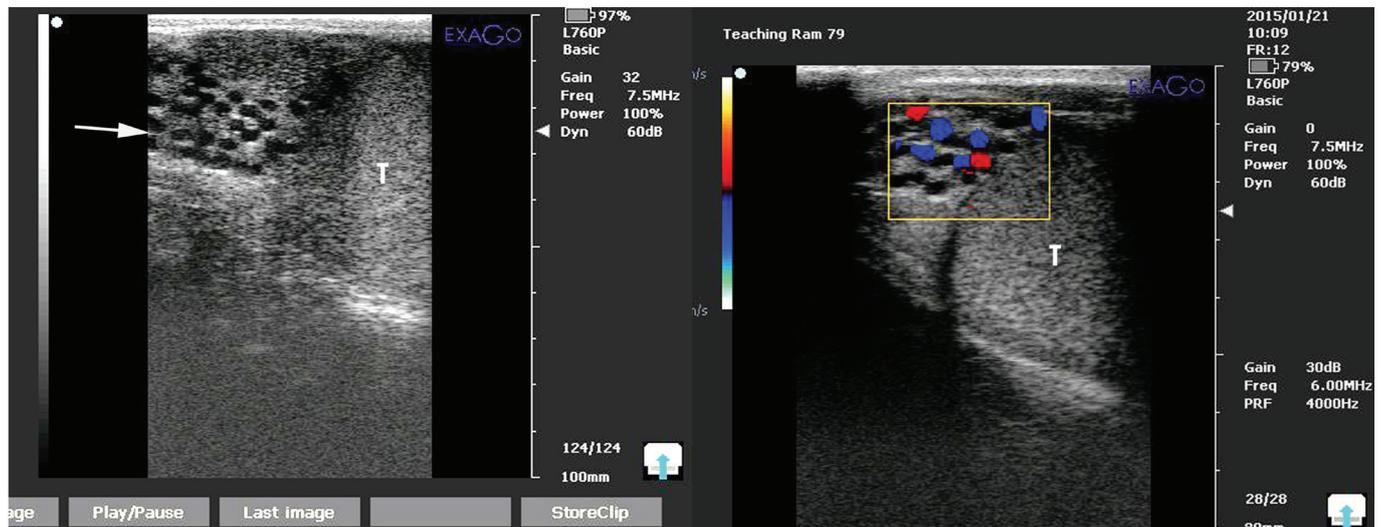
Ultrasonogram of the spermatic cord (arrow) and testicle (T). Right image shows color Doppler image of the testicular artery
